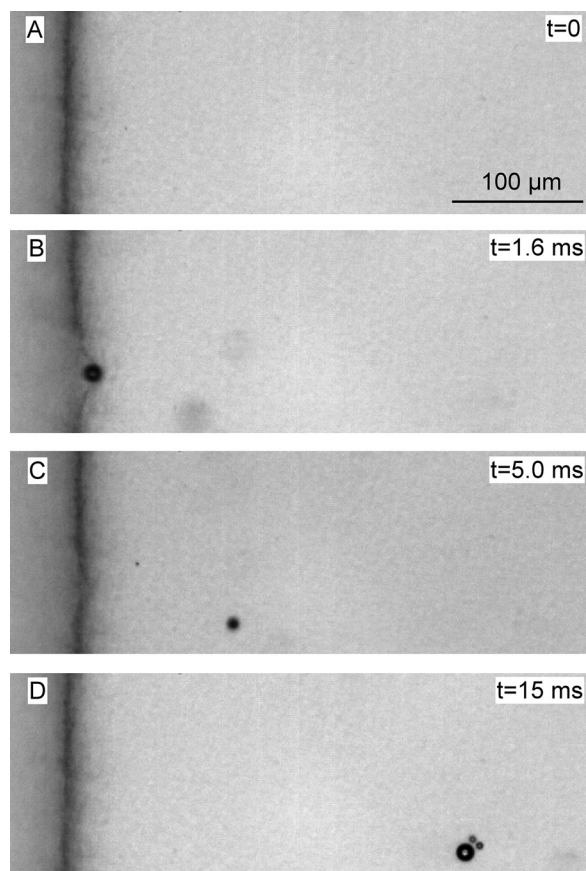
An example sequence from a fast frame camera movie (10 kfps). (a) Prior to ultrasound exposure, this frame shows the fluid channel on the left and fibrin clot to the right. (b) A microbubble brought to the boundary induces repeated local deformations under primary radiation forces associated with successive bursts (0.4 MPa) before penetrating the clot and translating (c). After coalescing with another bubble its translation continues and an intact bubble, along with two daughter bubbles that it has shed, remains after the cessation of ultrasound (d). Ultrasound propagation direction is from left to right (enhanced online) [URL: <http://dx.doi.org/10.1063/1.4816750.1>].
